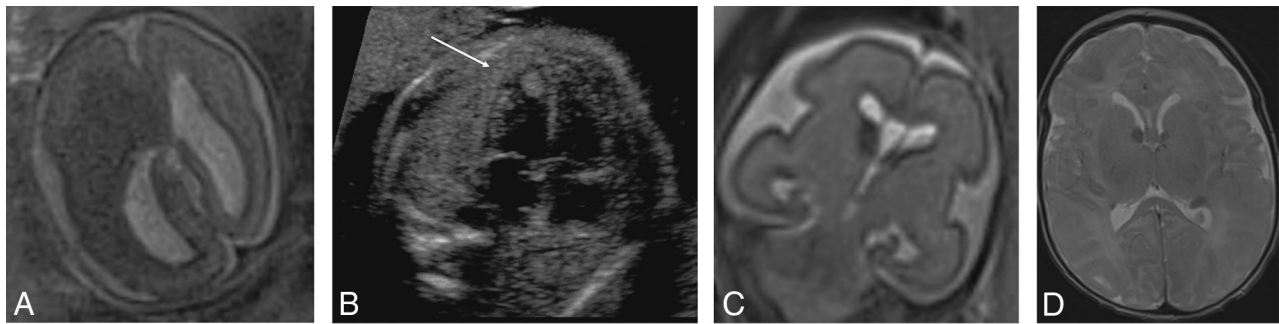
Tuberous sclerosis complex (A and B). Case 1. Dichorionic diamniotic twin at 22 weeks 5 days' gestation. T2-weighted single-shot FSE image demonstrates hemimegalencephaly and marked enlargement of the ipsilateral GE, which merges with a hypointense masslike lesion in the enlarged right cerebral hemisphere. The fetus had left ventricular cardiac rhabdomyoma on prenatal sonography (arrow, B); the findings likely represent tuberous sclerosis complex with an associated hemispheric malformation or, less likely, coexistent subependymal giant cell astrocytoma. No postmortem data or confirmatory genetic testing was available. Case 8. T2 single-shot FSE at 25 weeks gestation (C) and T2 FSE at 1-week postnatal imaging (D) demonstrate mild enlargement of the right GE, ipsilateral and mild ventriculomegaly on fetal MR imaging, and typical changes of tuberous sclerosis complex postnatally. The fetus' father also had tuberous sclerosis complex.
